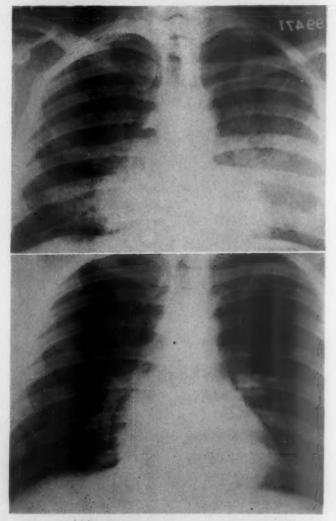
Case 1. A. (above) Roentgenogram taken on December 27, 1957, prior to biopsy. B. (below) Roentgenogram eight months later, showing almost complete resolution of the process, especially marked in the left lower lung field.
